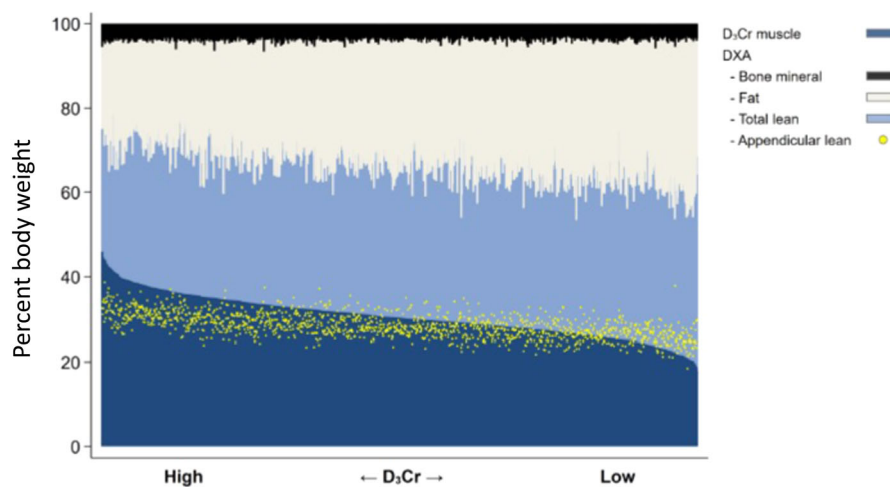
In >1300 older men, body composition was measured by using dual-energy x-ray absorptiometry (DXA) and D₃-creatine (D₃Cr) dilution to assess muscle mass.¹⁰ Yellow circles represent appendicular lean mass (ALM), also estimated by using DXA. Muscle mass is ranked from highest to lowest. Light blue represents nonmuscle lean mass. These data demonstrate that, in older men, muscle is only a component of and not strongly associated with lean body mass. There was no relationship between ALM and D₃Cr muscle mass.
